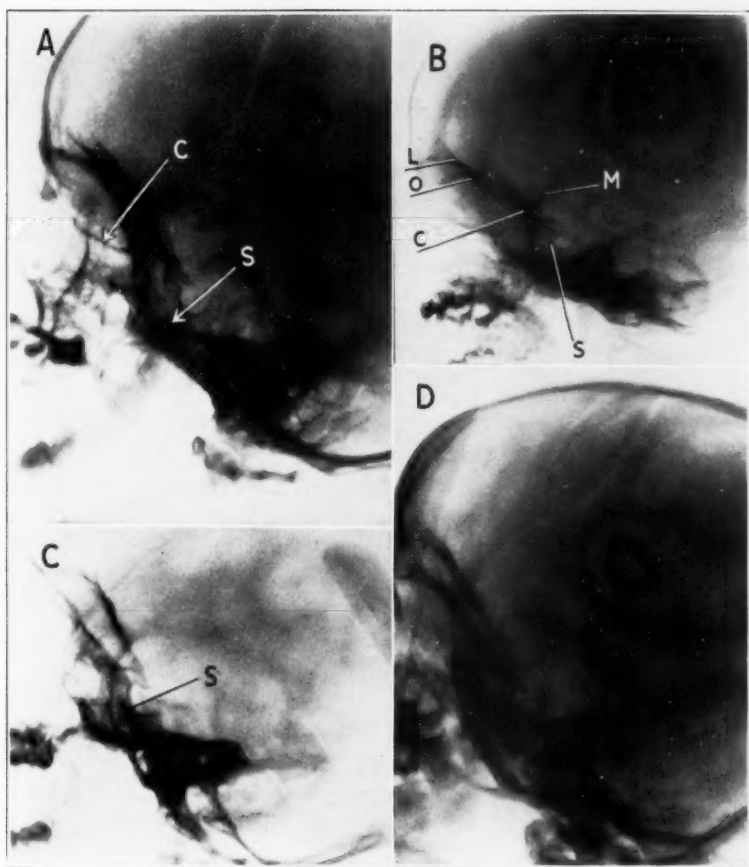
Roentgenograms of the skull. *A*, the skull of 5 year old child, with a normal base. Note the development of the sphenoid bone (*S*), the body of which is large. Later the sphenoid sinus will appear at this place. The cribriform bone (*C*) shows already rather a horizontal position. The upper margin of the orbits is markedly curved.
